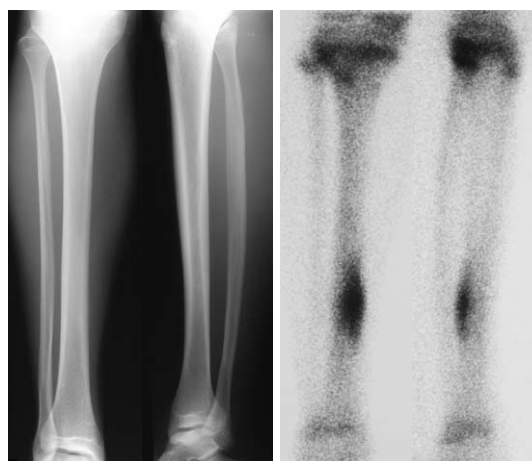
A case of stress fracture of the tibia diagnosed by technetium 99m-labeled bone scan. Although there were no abnormal findings on the plain radiographs of the tibia, the bone scan showed the uptake of technetium 99m in the tibial diaphysis. The localized focal uptake of technetium 99m suggests a stress fracture.
